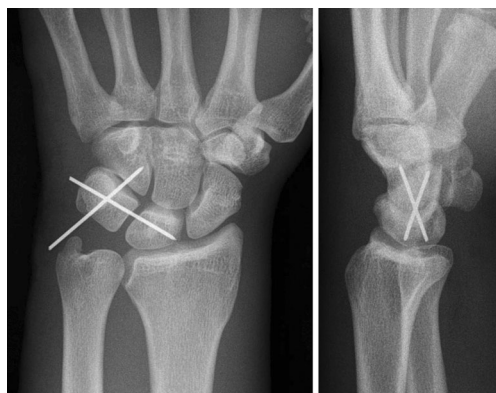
Plain radiographs taken 2 days after surgery: Dorsopalmar and lateral views show transfixation of triquetrum to hamate and lunate
